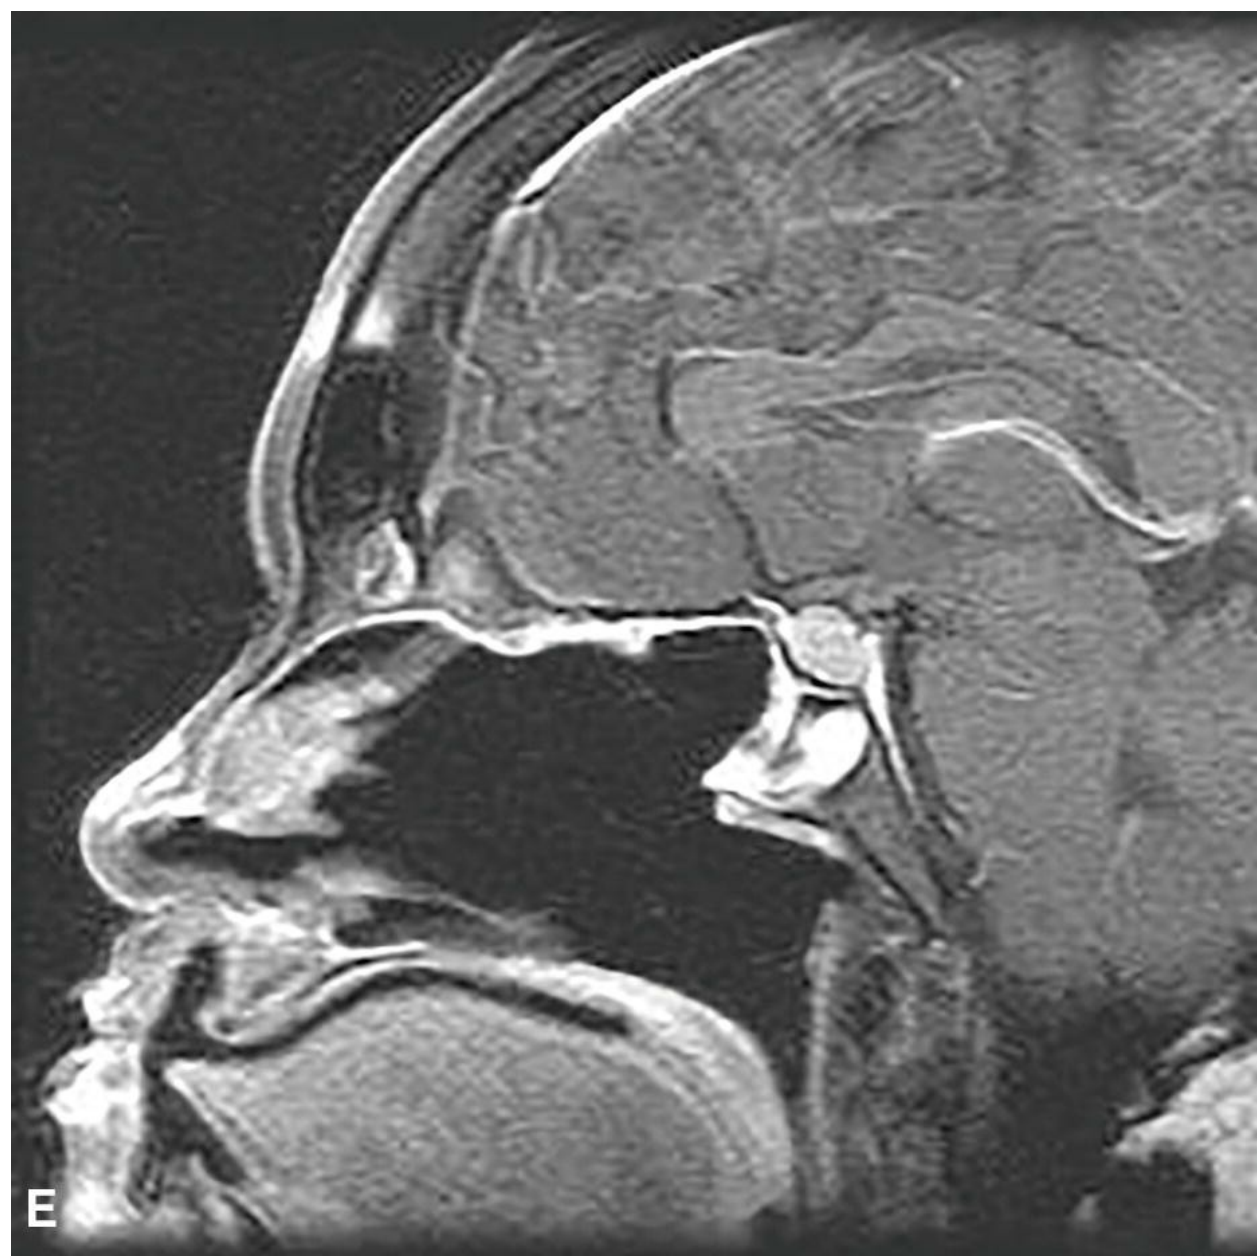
Hemangiopericytoma of the sinonasal region. Preoperative (A–C) and 3 years postoperative (D–F) MRI of a patient who underwent endoscopic resection of hemangiopericytoma of the sinonasal tract.
